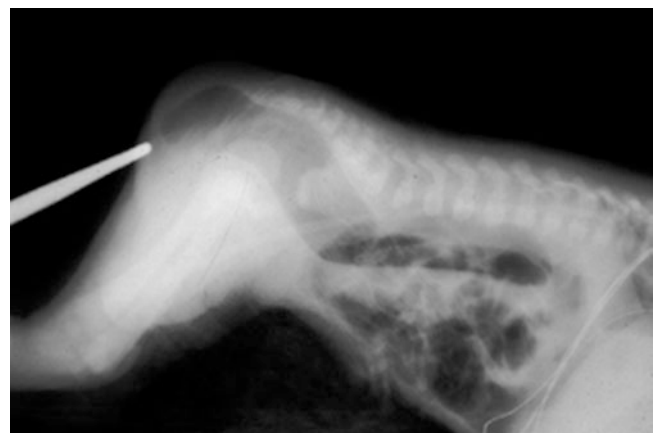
Invertogram or Wangenstein and Rice X-Ray, lateral cross table film with the baby in prone position [5]
